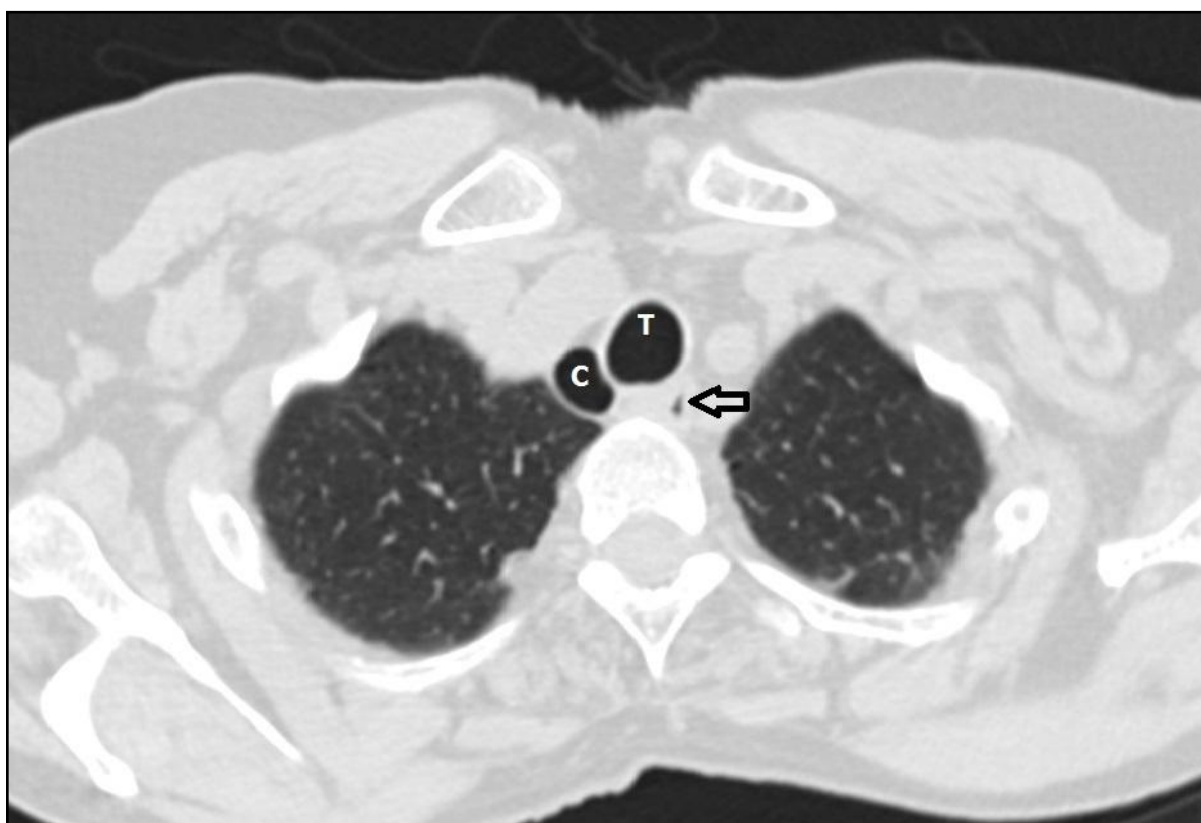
Plain CT axial section at the thoracic inlet.
